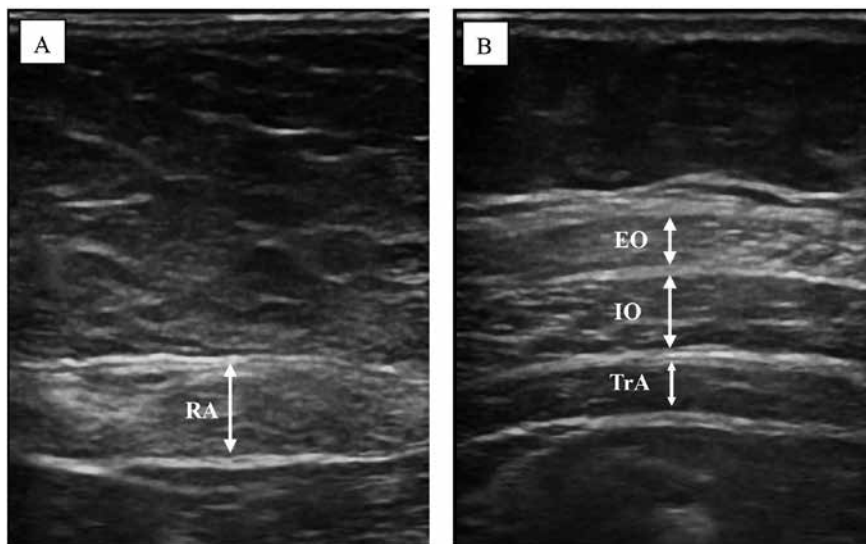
Abdominal muscle ultrasound images
